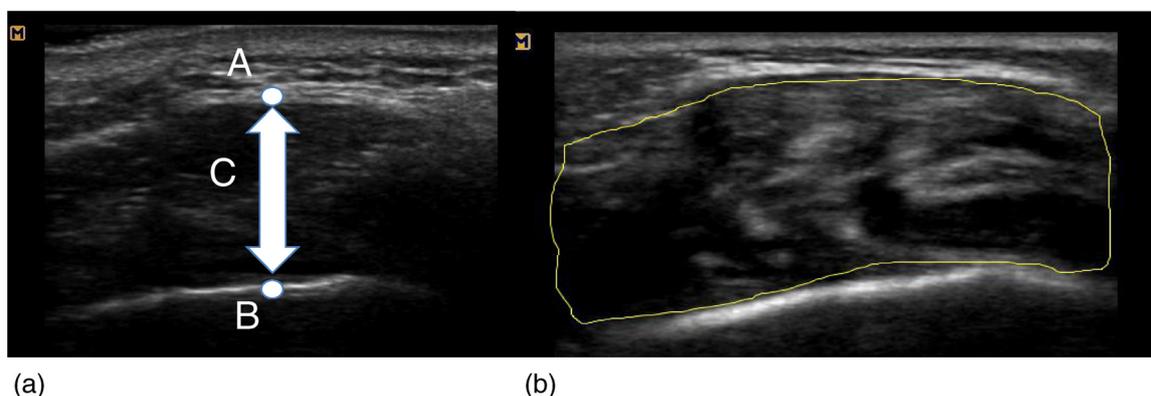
Masseter muscle evaluation by ultrasound diagnostic apparatus.
